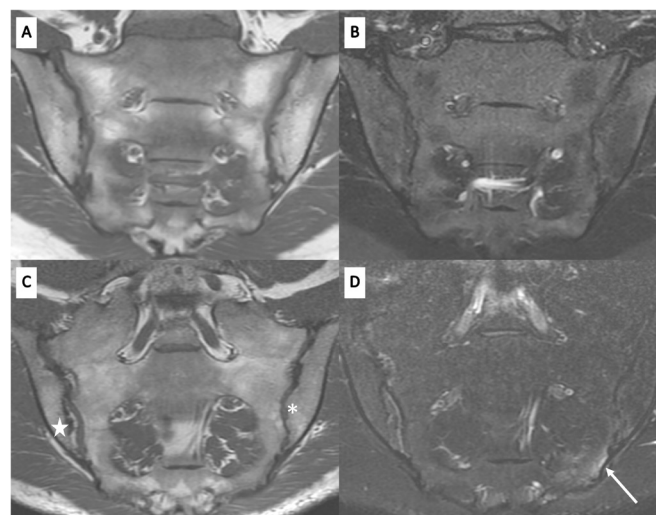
Examples of cases with disagreement between local MRI reports and central MRI readings. (A) and (B) are T1-weighted and STIR sequences of the same patient, respectively. Bilateral BME was reported in local MRI reports but not in central MRI readings. Dark areas on the STIR sequence (B) due to fat infiltration might give the impression that the normal bone marrow is bright. (C) and (D) are T1-weighted and STIR sequences of another patient. On the T1-weighted (C), there are backfill (star) and erosions (asterisk), which are not reported in local MRI reports but are in central MRI readings. On the STIR image (D), local MRI reports reported BME at the left sacroiliac joint, but central MRI readings did not, probably because it was considered either too small or more likely because the lesion is outside the joint (too caudal) (arrow) and central readers were asked only to score subchondral BME (ie, BME associated with the joint). The lesion may reflect enthesitis. BME, bone marrow oedema; STIR, short τ inversion recovery.
